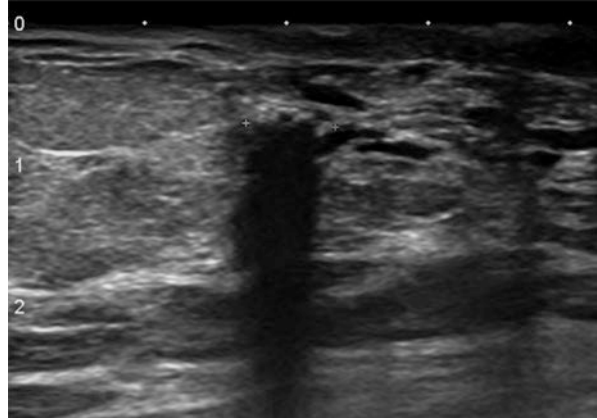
A 75-year-old patient undergoing breast cancer screening. Linear calcifications on the right papilla on mammography (a). US shows hyperechoic foci within the papilla (b). In color Doppler (c), these foci have a “twinkle” artifact
